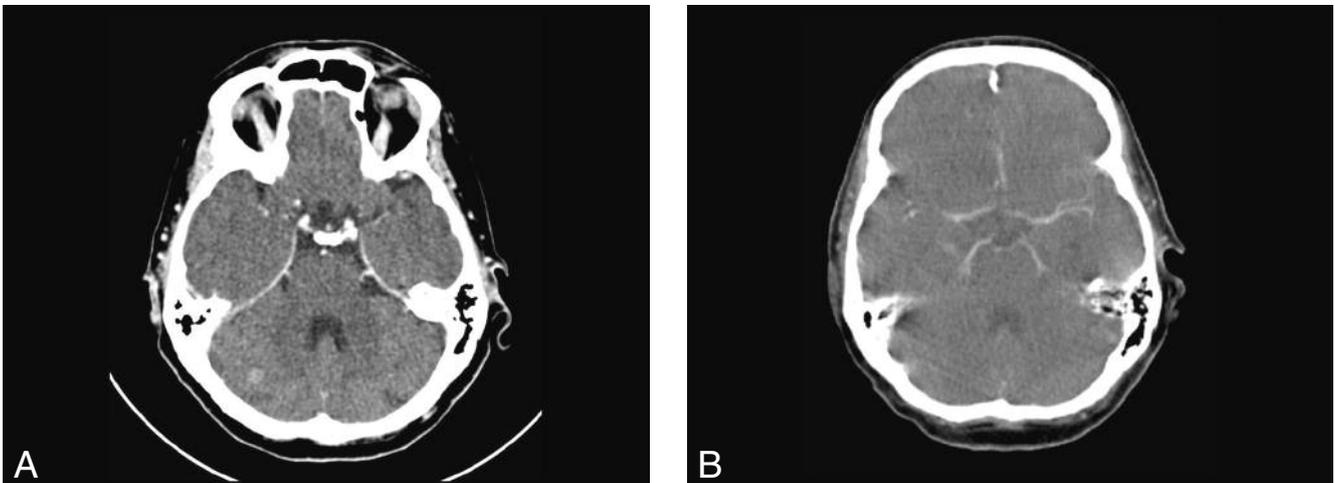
53-year-old woman with oatcell carcinoma with extensive disease. Patient had also brain metastasis. Diagnostic CT of the brain (A) was true positive showing a right cerebellar brain metastasis. This metastasis was not visualised on the brain CT of the integrated PET/CT (B) due to the inferior quality of this CT.
